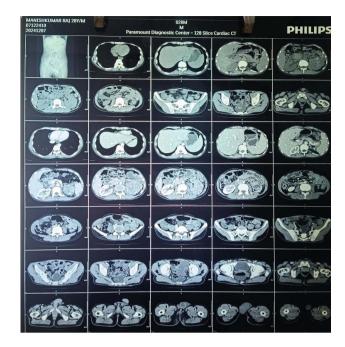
CT scan slices from level of the diaphragm to the pubic symphysis with IV contrast.
